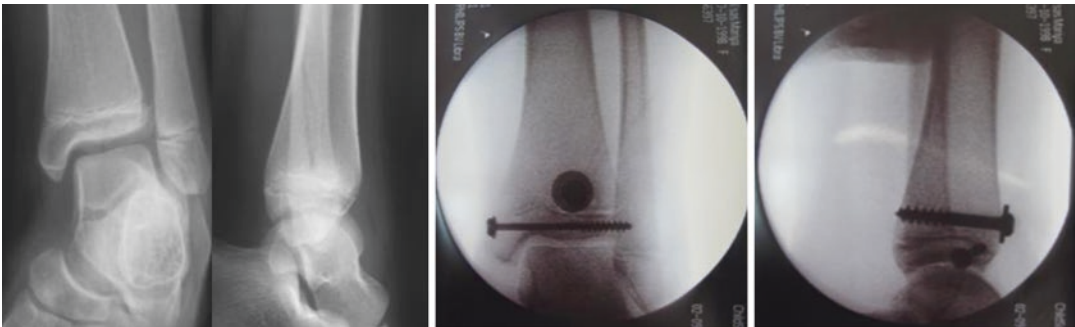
X-rays of distal metaphyseal tibia fracture treated with compression screws
